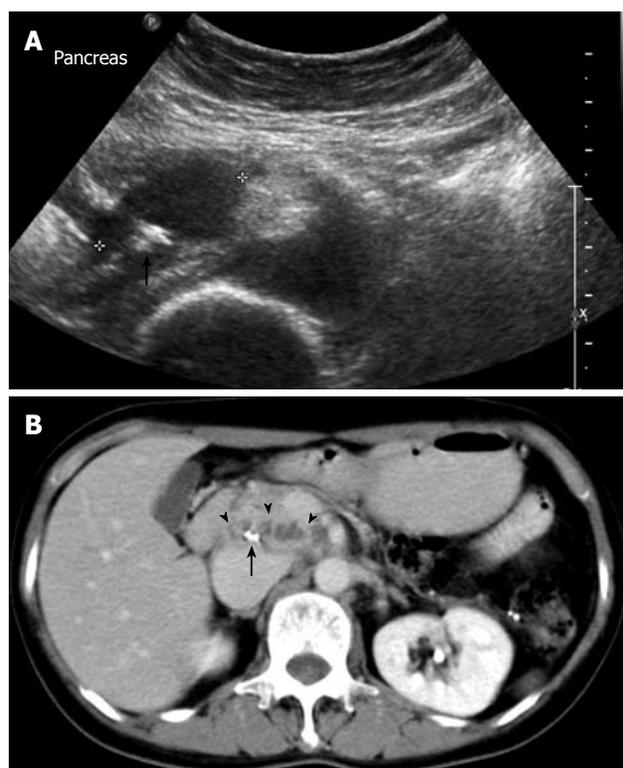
Abdominal US and CT at admission. A: Abdominal US revealed an irregularly contoured, hypoechoic, cystic lesion in the head of the pancreas, with calcification at the center of the mass (arrow); B: abdominal CT demonstrated an inhomogeneous lobulated multicystic mass of 4.5 cm × 2.0 cm in the head and uncinate process of the pancreas, with central calcification (arrow).
